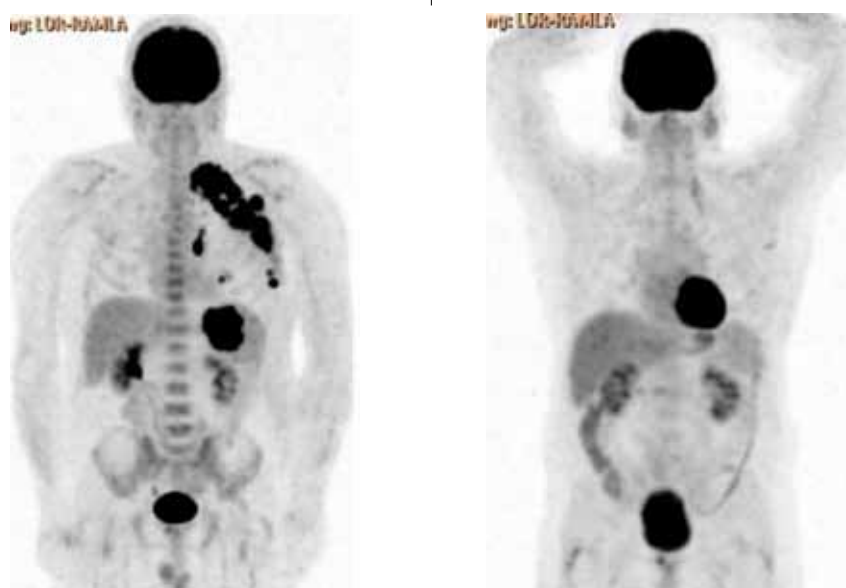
Positron Emission Topography (PET) images before (left) and after (right) Rituximab containing treatment for a patient with lymphoma. There is physiological uptake of fludeoxyglucose (FDG) in the brain, heart and bladder. Lymphomas are metabolically active and take up FDG. All lymphoma deposits have disappeared after completion of treatment (right), with only physiological uptake remaining.
